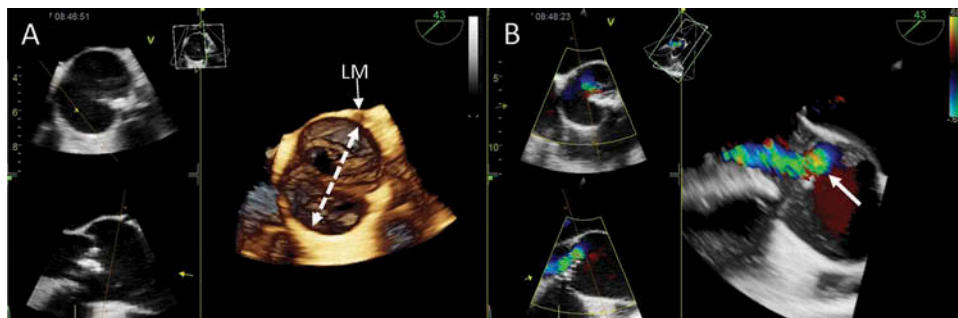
Bicuspid aortic valve regurgitation. Three-dimensional transesophageal echocardiography of a patient with type 0 bicuspid aortic valve. Panel A shows the biplane view of the aortic valve with the short- and long-axis views. The reconstructed 3-dimensional volume rendered image is visualized from the aortic side. Note the dilatation of the aortic root (59 mm, double arrowhead). Three-dimensional color Doppler flow data show the regurgitant jet (arrow) with a planimetered 3-dimensional vena contracta area of 0.6 cm² indicating severe aortic regurgitation. Abbreviations: LM = left main.
